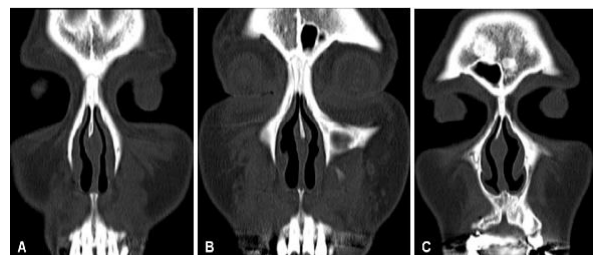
Coronal computed tomography image of the paranasal sinuses. The image shows bilateral frontal (A) sinus aplasia, (B) right frontal sinus aplasia, and (C) left frontal sinus aplasia.
